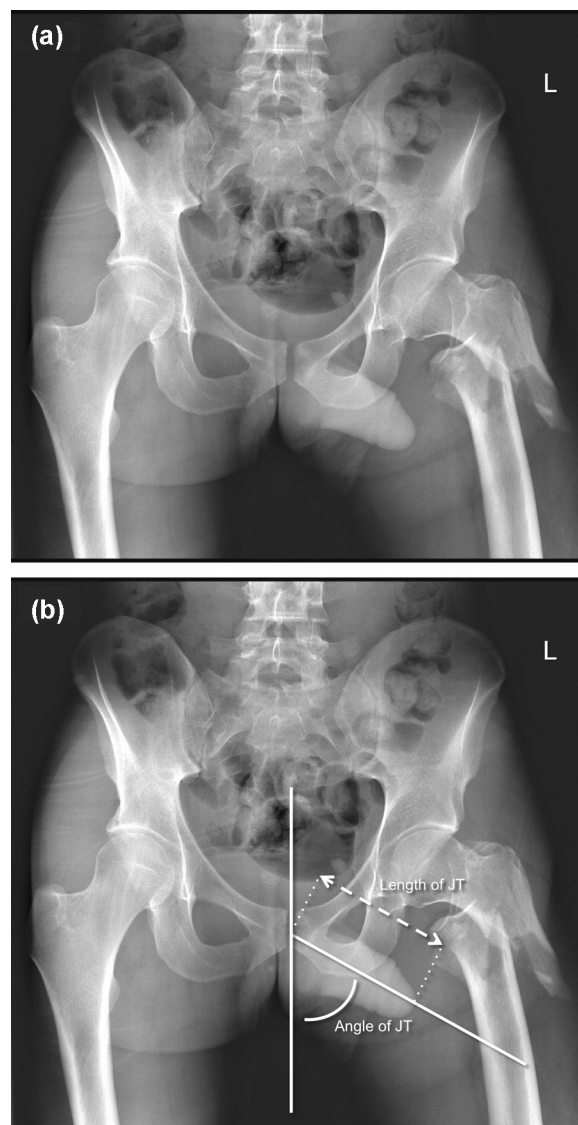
(a) AP radiograph of fracture of left proximal femur (b) with overlying measurements of length and angulation.
